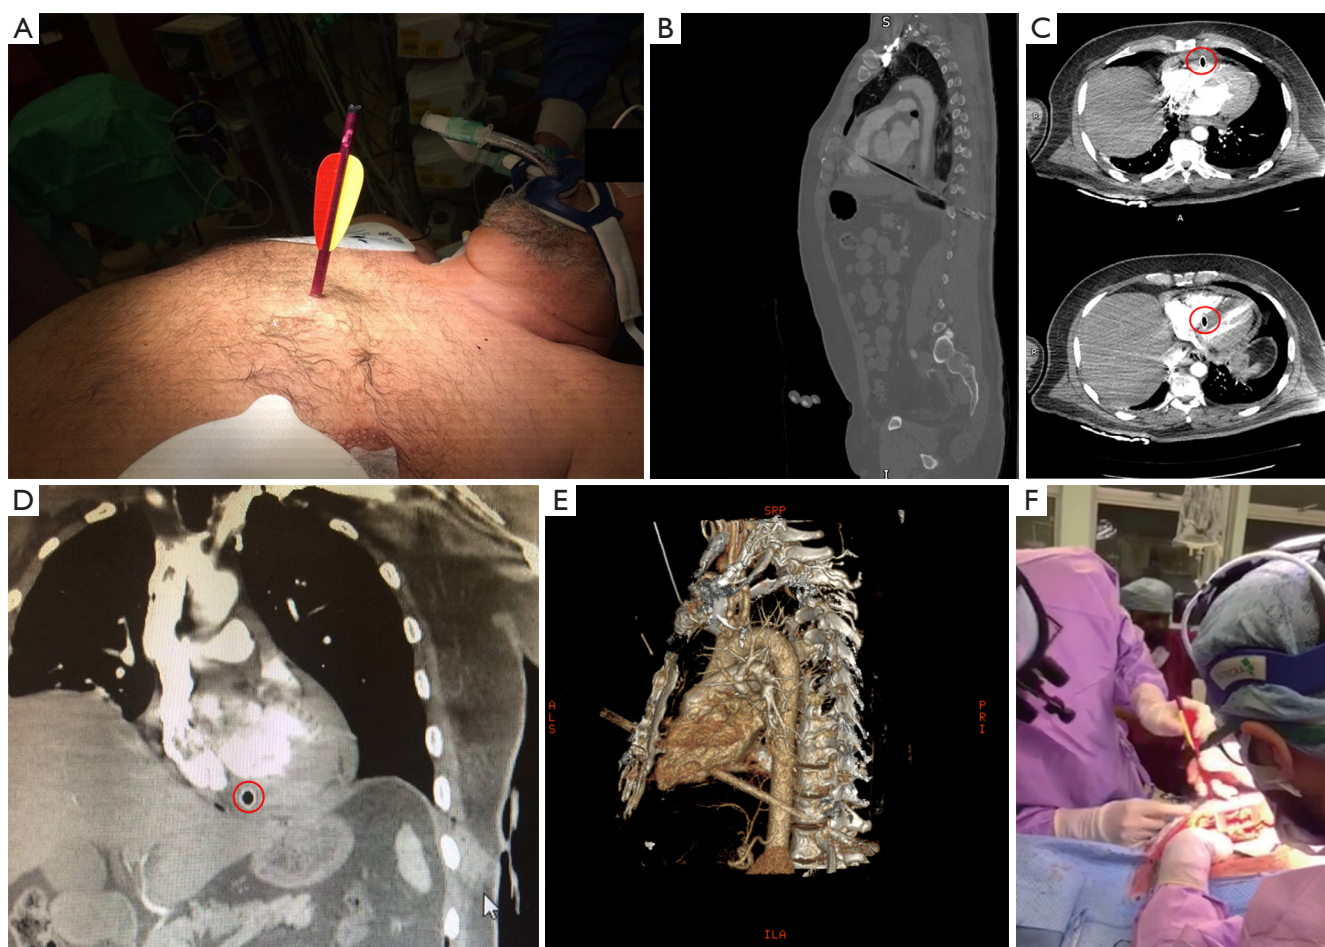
Patient's presentation at the emergency department, instrumental examination and arrow retrieval during surgery. (A) Patient's presentation; (B,C,D) different computed tomography scan planes (red circles pointing out the arrow); (E) 3D volume rendering reconstruction; (F) arrow retrieval.
